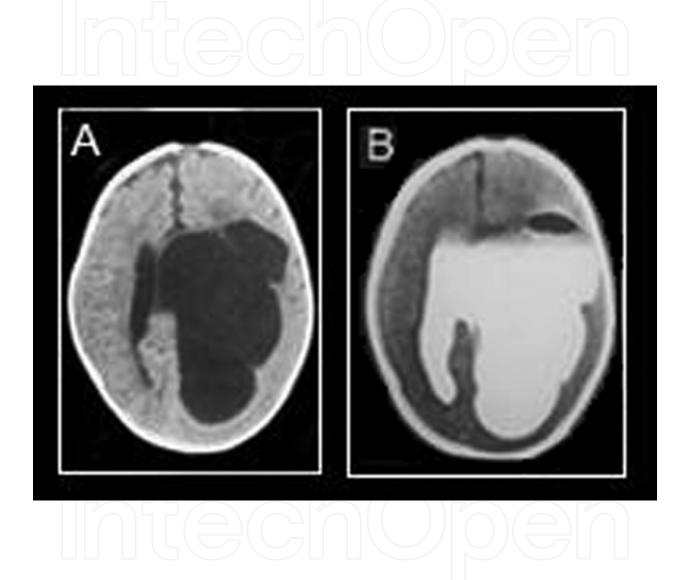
A, Preoperative CT scan axial view of a 5 months old male patient with multiloculated hydrocephalus. B, postoperative CT ventriculography performed 1 week after surgery showing the contrast material evenly filling the entire ventricular system confirming communication among all cavities. The presence of air within the cyst is an indication of successful fenestration [Reprinted with permission from El-Ghandour NM (2008). Endoscopic cyst fenestration in the treatment of multiloculated hydrocephalus in children. *J Neurosurg Pediatr*, Vol.1, No. 3, (March 2008), pp:217-222, ISSN 1933-0707].
